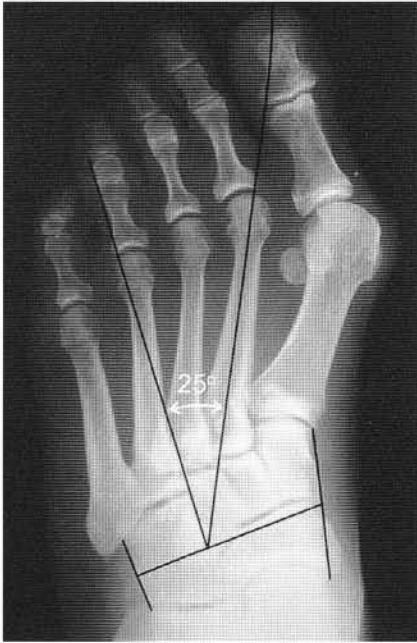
Hallux Valgus with metatarsus adductus. This is 56-year-old female who presented with severe deformity and a large medial bunion. Preoperative AP radiograph shows the metatarsus adductus angle which measured at 25 degrees. A first MTP joint arthrodesis was performed with curettage joint resection.
